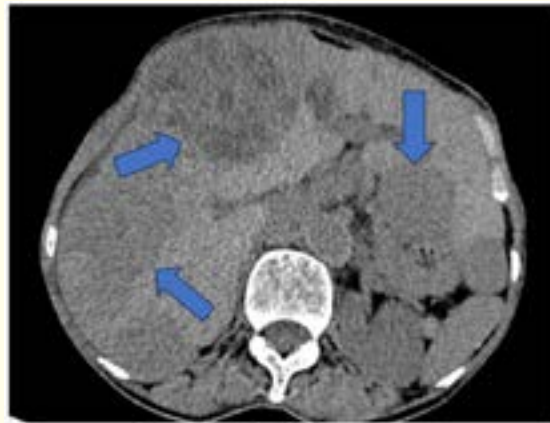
Axial contrast-enhanced CT scan demonstrating marked hepatomegaly with multiple disseminated heterogeneous hypodense lesions (blue arrows) involving both hepatic lobes, reflecting extensive hepatic tumor burden in a patient with primary hepatic melanoma.
